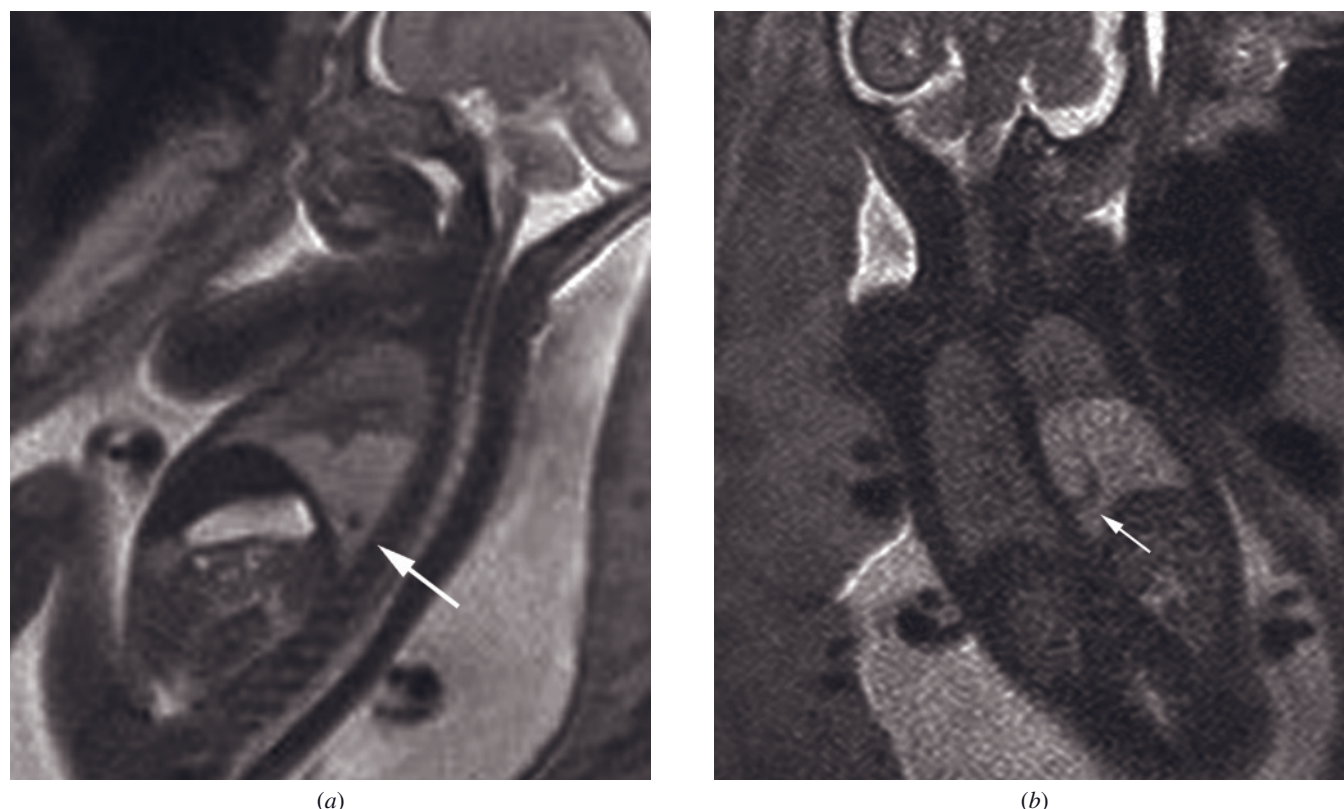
Bronchopulmonary sequestration. Sagittal (*a*) and coronal (*b*) T2-weighted SS-ETSE images in a fetus at 25 weeks of gestation demonstrate a mildly hyperintense mass in the left lower lobe. A flow void extends from the aorta into the pulmonary mass (arrows), suggesting systemic arterial supply to a bronchopulmonary sequestration.
